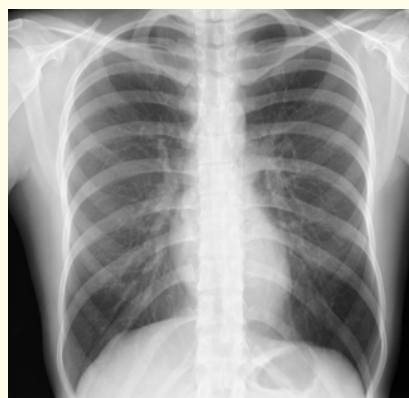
Plain chest X-ray with no pathological findings.
